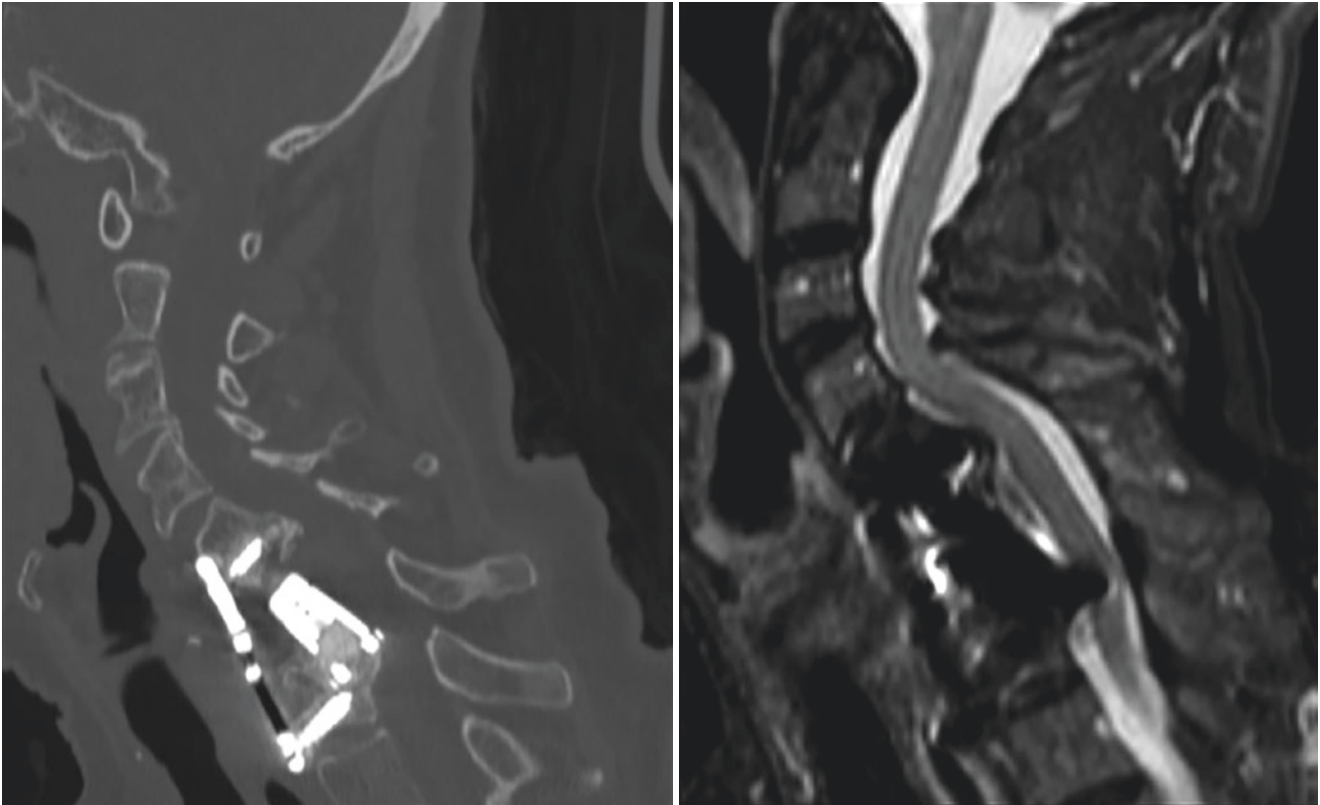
Sagittal cervical CT scan (left) and MRI scan (right) documenting C6-C7 intersomatic cage displacement
